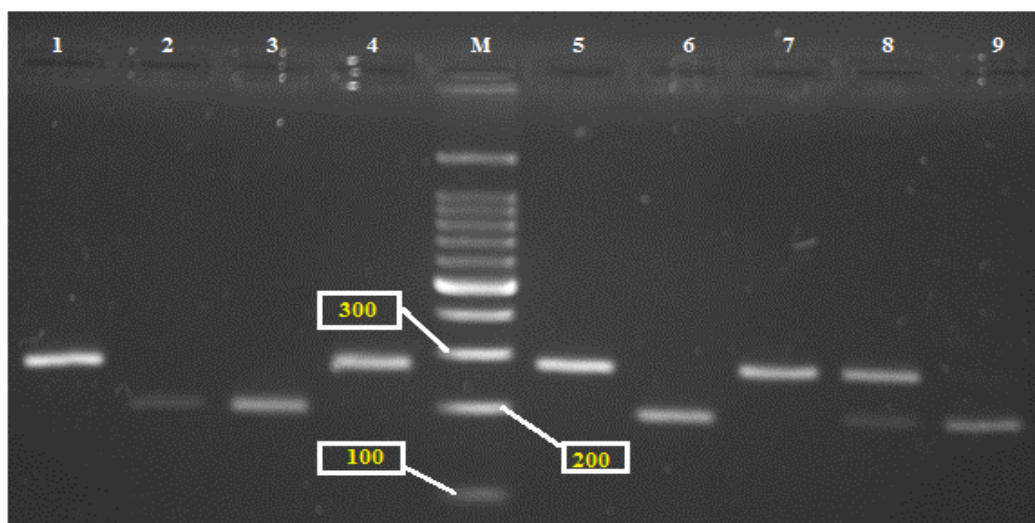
The FokI restriction digested PCR product profile of VDR gene. Lane M; DNA Marker; Lane 1,4,5, and 7 show CC genotype, Lane 8 shows CT genotype, Lane 2,3,6 and 9 show TT genotype.
